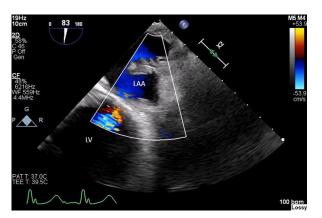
Midesophageal two-dimensional TEE 2-chamber view with color flow Doppler during diastole showing blood flow through the LAA prior to surgery.
